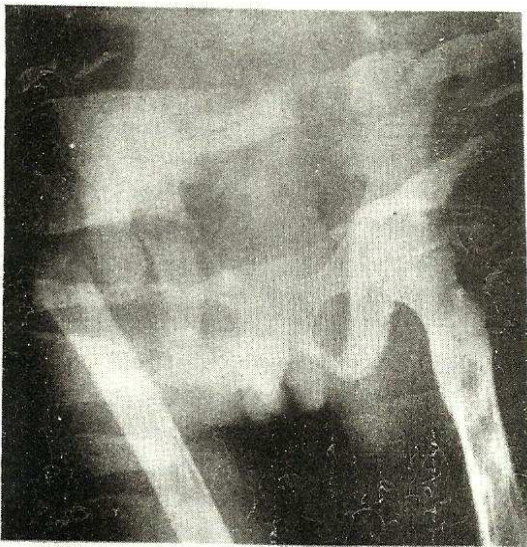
Radiograph of a right femoral neck fracture in a patient with Hb S showing infarction of the right femoral neck and both femoral shafts.
